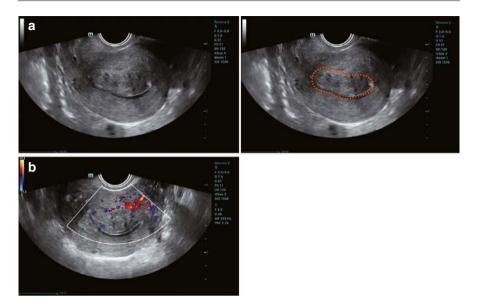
(a) Type 1 Fibroid: B-mode ultrasound shows a fibroid in the posterior wall of the uterus, with most of it inside the uterine cavity. The fibroid is circled in orange. (b) Color Doppler shows the blood supply to the fibroid, originating from the posterior wall of the uterus
